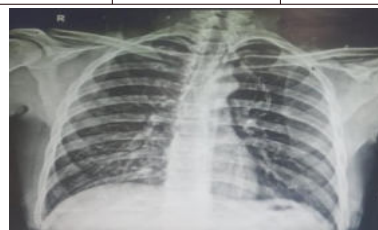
Chest X-ray PA view of case number 6 on admission
